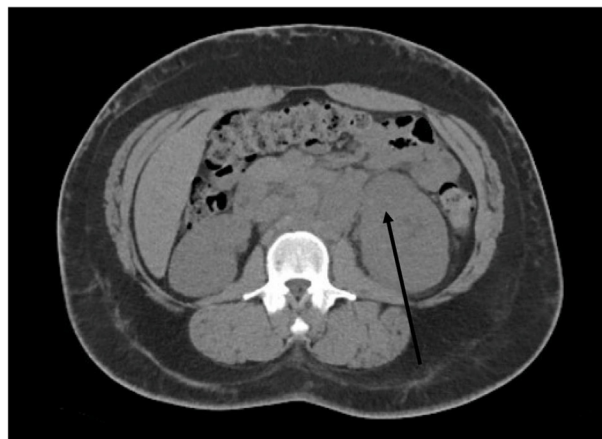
CT abdomen without contrast showed large lobulated soft tissue structures in left retroperitoneum suspected to be lymph node (single arrow).
